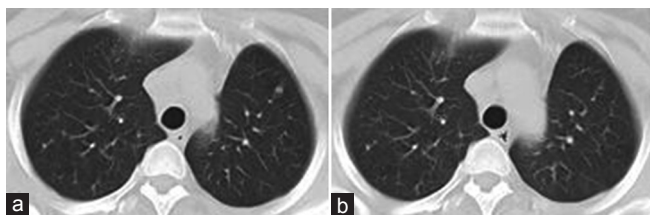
(a) Computed tomography of Case 2: Nonsmall cell lung cancer patient before tyrosine kinase inhibitor treatment. (b) Computed tomography of Case 2: Nonsmall cell lung cancer patient after tyrosine kinase inhibitor treatment
